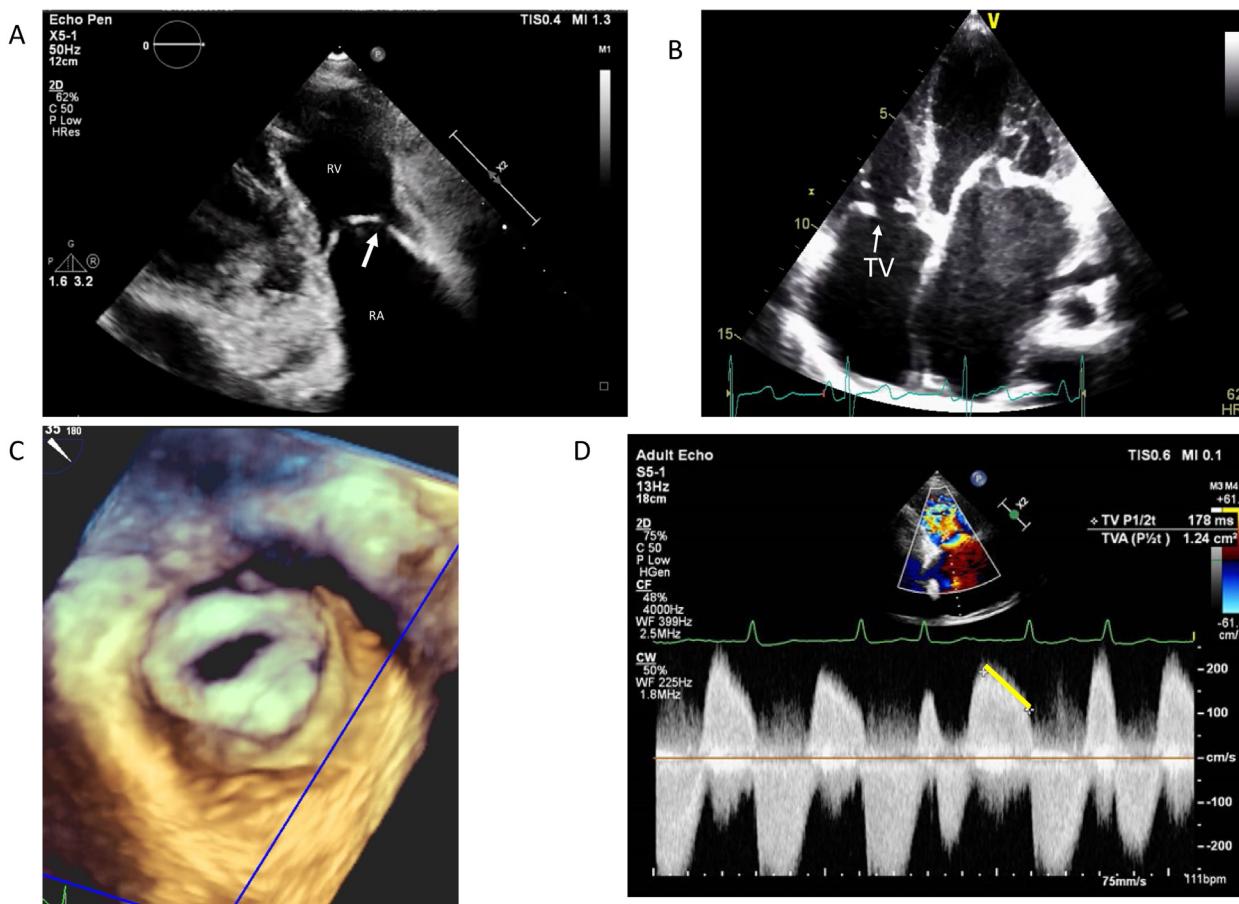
Rheumatic tricuspid valve. (A) A 2D echocardiographic image of a stenotic TV in the right ventricular inflow view. Note the doming leaflets (arrow), with reduced separation of the leaflet tips and enlarged RA. *Figure courtesy of Dr. Satish Govind, Bengaluru, India.* (B) A 2D echocardiographic image of a stenotic TV (arrow) in the apical 4-chamber view. *Figure courtesy of Dr. Manish Bansal, New Delhi, India.* (C) En-face view of thickened, stenotic TV with commissural fusion seen from the right atrial view using 3D echocardiography. (D) A continuous-wave Doppler recording through the rheumatic TV shows the PHT of 178 ms, and TVA estimated to be 1.24 cm^2 per the PHT method (yellow line).
